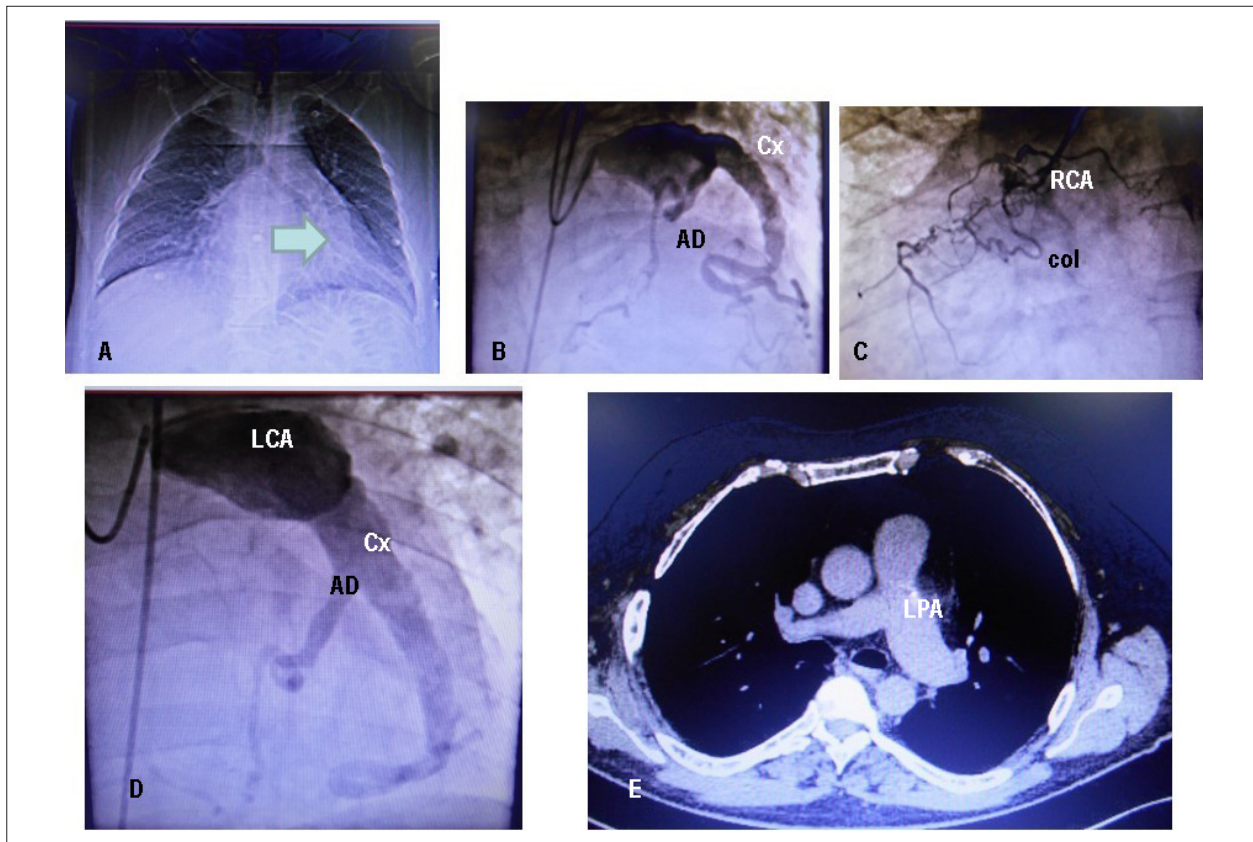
Chest X-ray in PA highlights normal cardiac area and pulmonary vascular tissue. Left ventricular border shows a dense rectilinear image that corresponds to the left coronary artery aneurysm (arrow). Coronary angiography points out the aneurysm of the trunk of the left coronary artery and the circumflex artery (B and D), the obstruction of the anterior descending artery (B and D) and the right coronary artery (C). It is observed filling of this artery, with total obstruction, from the left coronary and the distal part of the AD. Chest tomography shows dilatation of the left pulmonary artery, and normal caliber of ascending and descending aorta (E).
